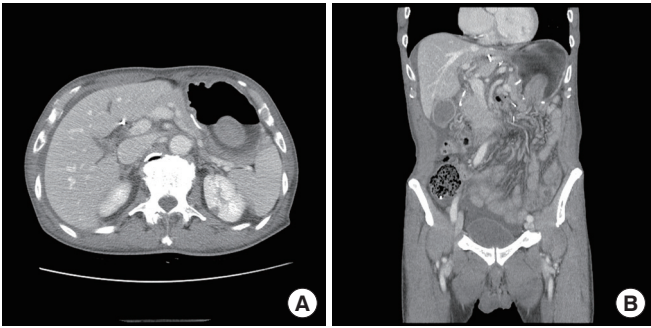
Abdominal computed tomography scans showing an elevated lesion protruding to the remnant stomach. (A) Axial and (B) coronal views.
